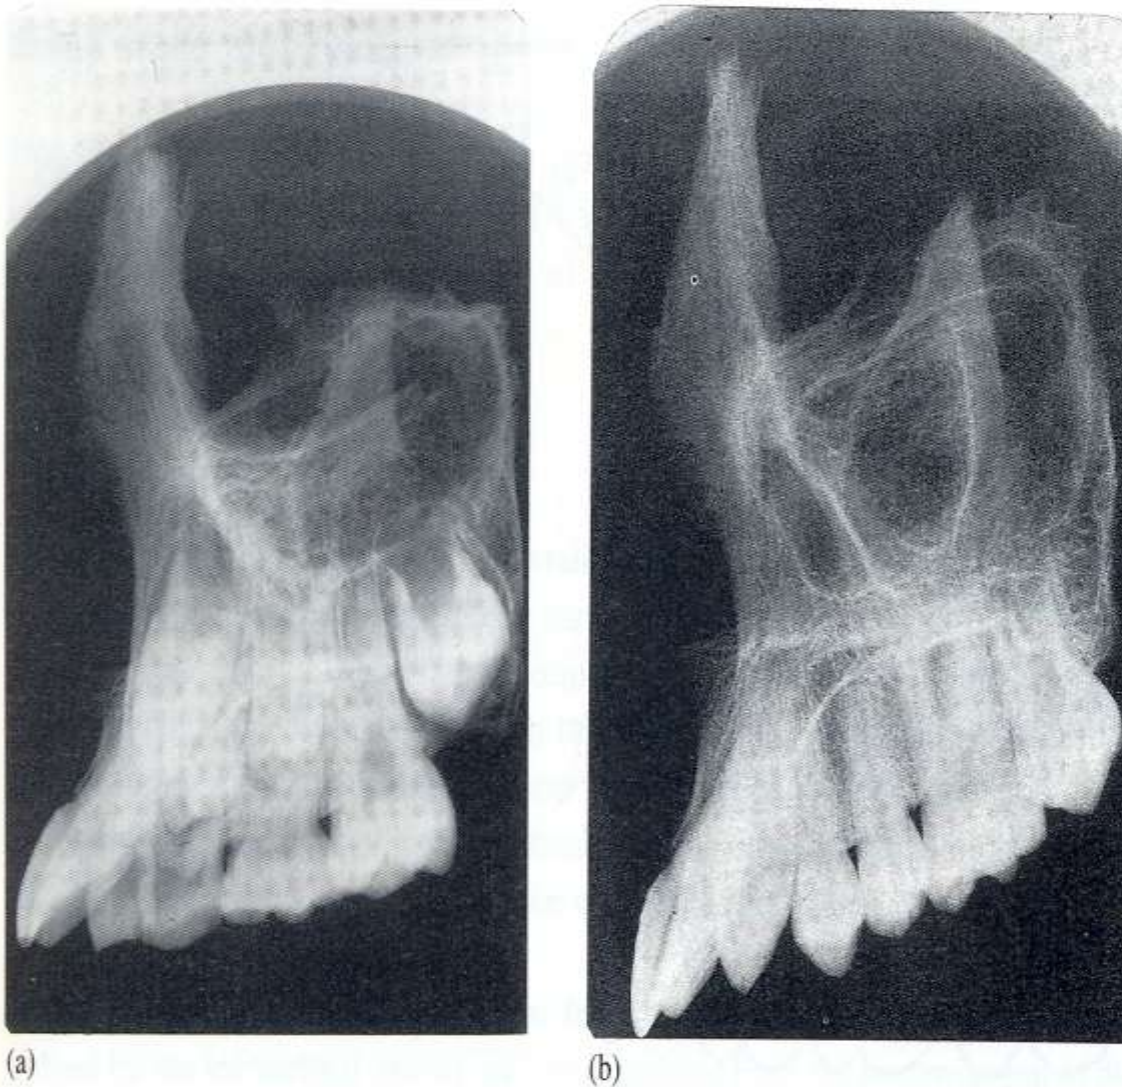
Lateral radiographs of right disarticulated maxillae in (a) an 8-year-old; and (b) a 14-year-old, showing the increase in height of the sinus with the eruption of the permanent premolars and molars
